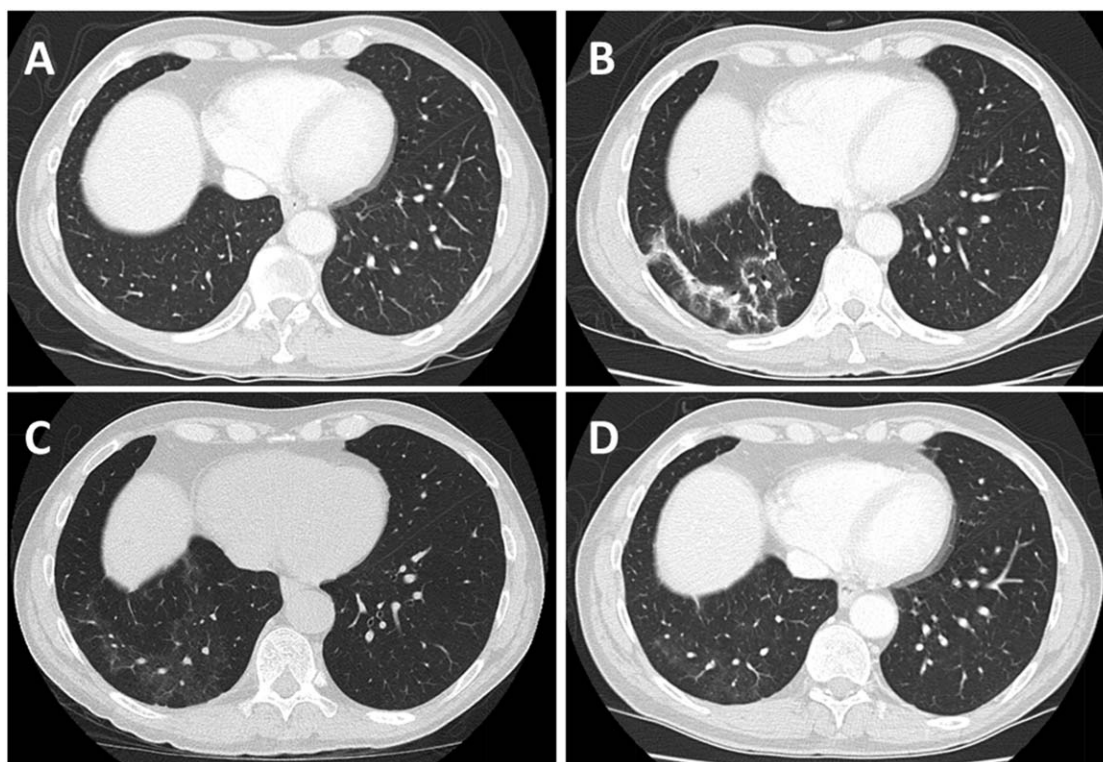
Pneumonitis. Chest computed tomography scans of a 72-year-old male with stage IV lung adenocarcinoma on second-line nivolumab. (A): After three cycles. (B): Grade 1 cryptogenic organizing pneumonia-like pneumonitis after eight cycles. (C): Improvement after 4 weeks of steroids and holding nivolumab; then steroids were tapered slowly over 4 more weeks, and nivolumab was restarted. (D): After 10 cycles.
